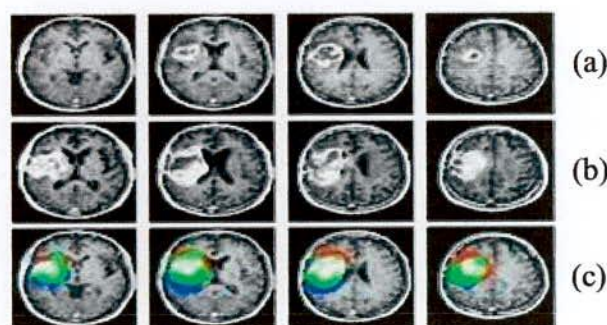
Classifier based segmented image. (a) Brain MRI image with edema (b) Brain MRI image with tumor (c) Brain MRI image with edema & tumor marked with different color.
